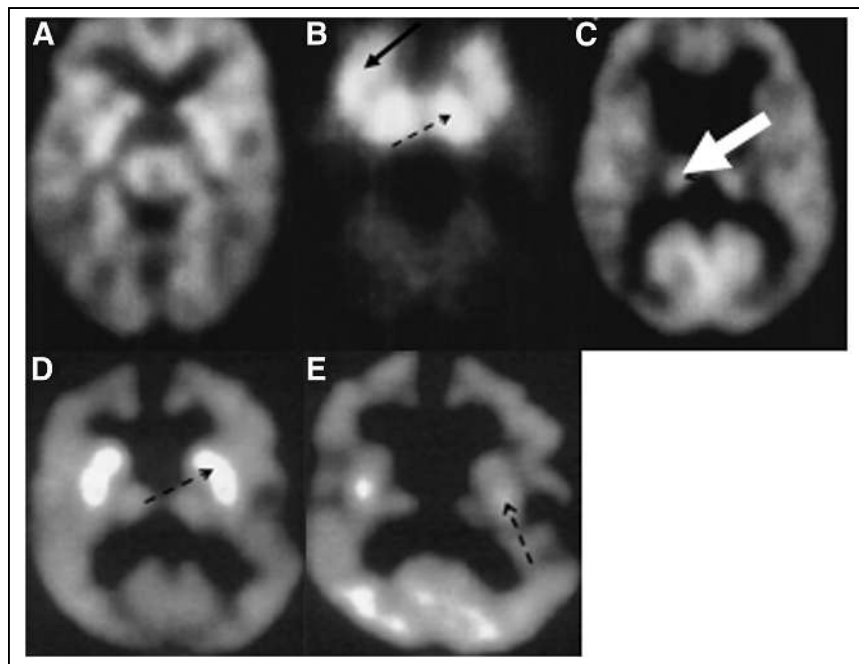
(A–C) ^{18}F -FDG PET scans of 3 children with propionic acidemia at different stages of disease: at age 1 mo (A), this baby shows relatively normal pattern of glucose metabolism for age; this 2-mo-old infant (B) shows intense hypermetabolism in basal ganglia (solid arrow) and thalamus (dashed arrow); this 2-y-old child (C) shows relatively normal glucose metabolism in thalamus (dashed arrow), but basal ganglia shows no metabolic activity. (Reprinted with permission from Elsevier (23).) (D and E) ^{18}F -FDG PET images of boy with ethylmalonic aciduria: at 2 y of age (D), intense bilateral hypermetabolism is seen in caudate nucleus and putamen (dashed arrow); when scanned again at age 3 y (E), there has been evolution of hypermetabolism to hypometabolism (dashed arrow). (Reprinted with permission from Elsevier (24).)
